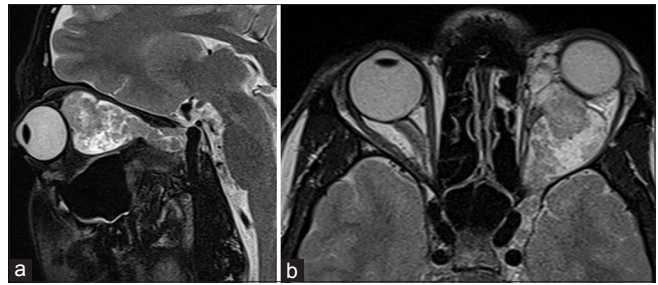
(a) Sagittal T2-weighted image magnetic resonance imaging showing an oblong-fusiform mass in the retrobulbar region of left orbit extending into superior orbital fissure and the left cavernous sinus causing proptosis. (b) Axial T2-weighted image showing heterogeneously hyperintense mass in orbit and extending into cavernous sinus
